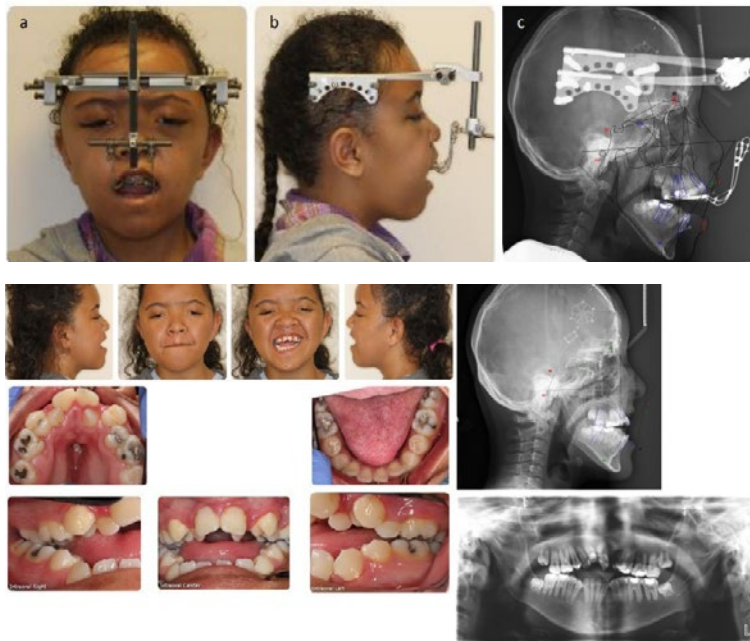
Case 2 - 14 years of age. (a, b, c) Facial photographs and lateral cephalometric radiograph obtained during the activation phase of the Le Fort II DO with zygomatic repositioning. (d) Orthodontic records taken after removal of distraction appliances.
